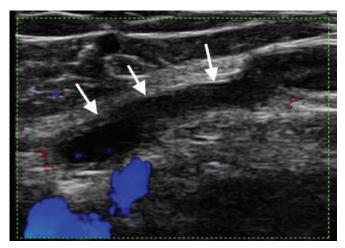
Ultrasound scan along the length of the inguinal canal showing a persistent canal of Nuck (arrows).
